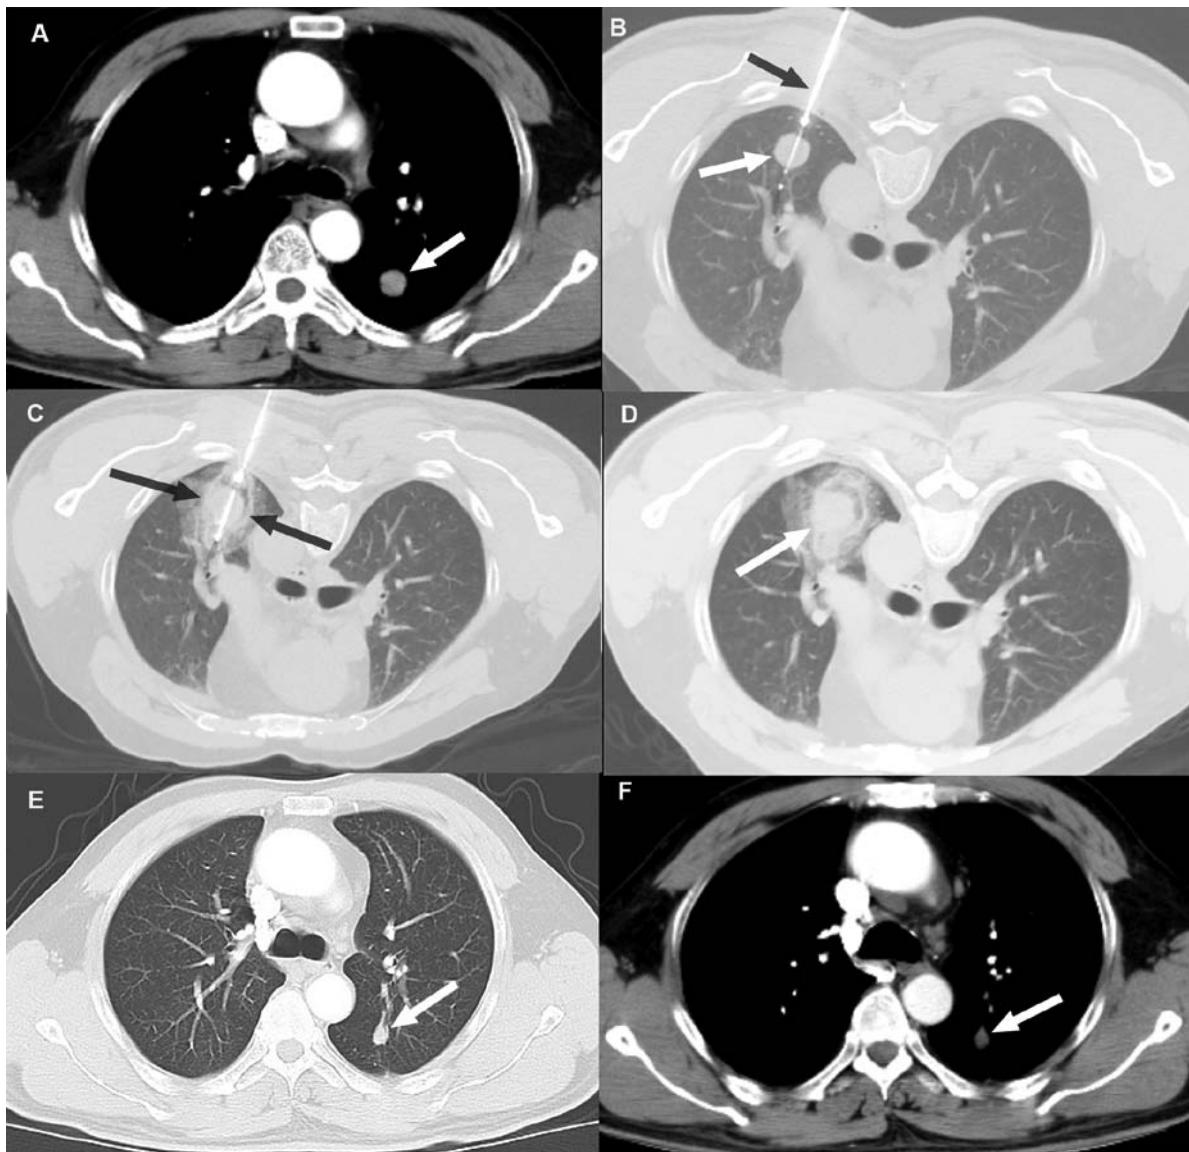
Local disease control at six months post-CA in a 48-year old male patient with a 14.8-mm left lower lobe primary tumor. (A) Pre-ablation contrast-enhanced axial CT images in soft-tissue windows showing a primary tumor (white arrow). (B and C) Axial CT images during the CA procedure showing (B) cryoprobe (black arrow) positioned within the tumor (white arrow) and (C) excellent coverage of tumor with the ice ball (between black arrows) following freezing. (D) Images captured immediately post-CA. (E and F) Contrast-enhanced follow-up CT images in (E) lung and (F) soft-tissue windows 6 months after CA demonstrating tumor size reduction without evidence of enhancement (white arrow). CA, cryoablation.
